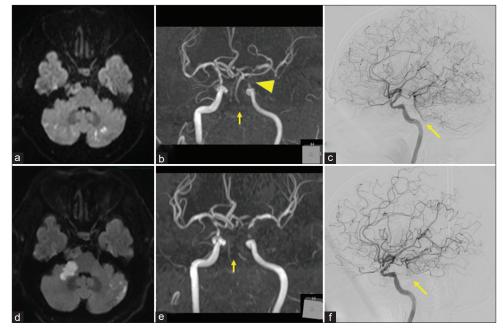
(a) Diffusion-weighted MRI showed bilateral cerebellar infarctions, and (b) MRA showed the left ICA stenosis (arrowhead) and the complete occlusions of the bilateral vertebral arteries (arrow) on admission. (c) Lateral view of the angiography showed retrograde filling of the BA and AICA from the right PCoA (arrow) on admission. (d) Diffusion-weighted MRI showed infarctions in the right cerebellar peduncle and the left cerebellar hemisphere, and (e) MRA showed poor visualization of the BA. (f) Lateral view of the angiography showed a decline in retrograde BA blood flow (arrow) compared to the image at admission. AICA: Anterior inferior cerebellar artery, BA: Basilar artery, ICA: Internal carotid artery, MRI: Magnetic resonance imaging, MRA: Magnetic resonance angiography, PCoA: Posterior communicating artery.
